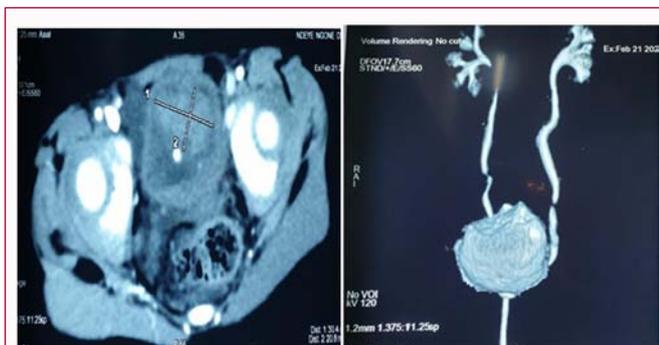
Uro-CT images showing bladder dome tumor.
